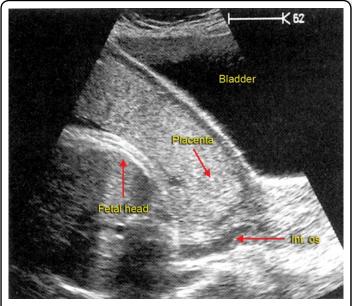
Transabdominal sonogram showing anterior placenta previa (Type –II)
